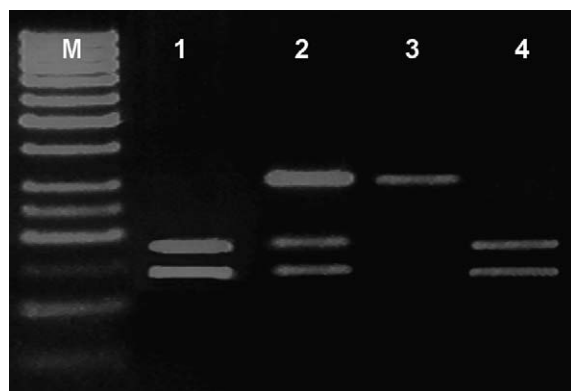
Analysis of the P21 3'UTR genotypes by RFLP: M – 50 bp ladder; lanes 1 and 4, homozygous CC; lane 2, heterozygous CT; lane 3, homozygous TT.
